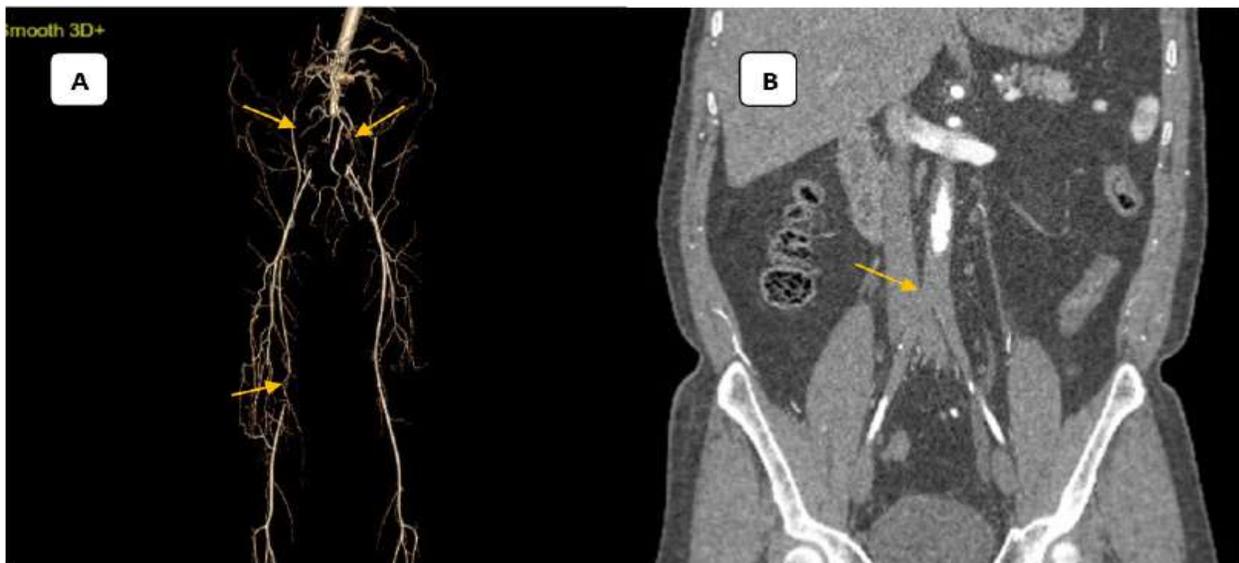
(A) CT angiography VR image shows complete aorto iliac occlusion and right SFA occlusion
